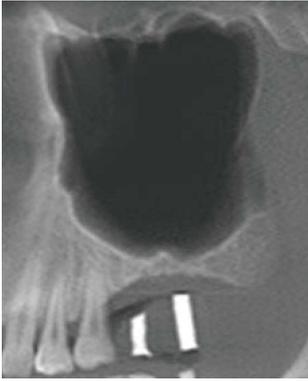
Panoramic view from cone beam computed tomography showing septum.
